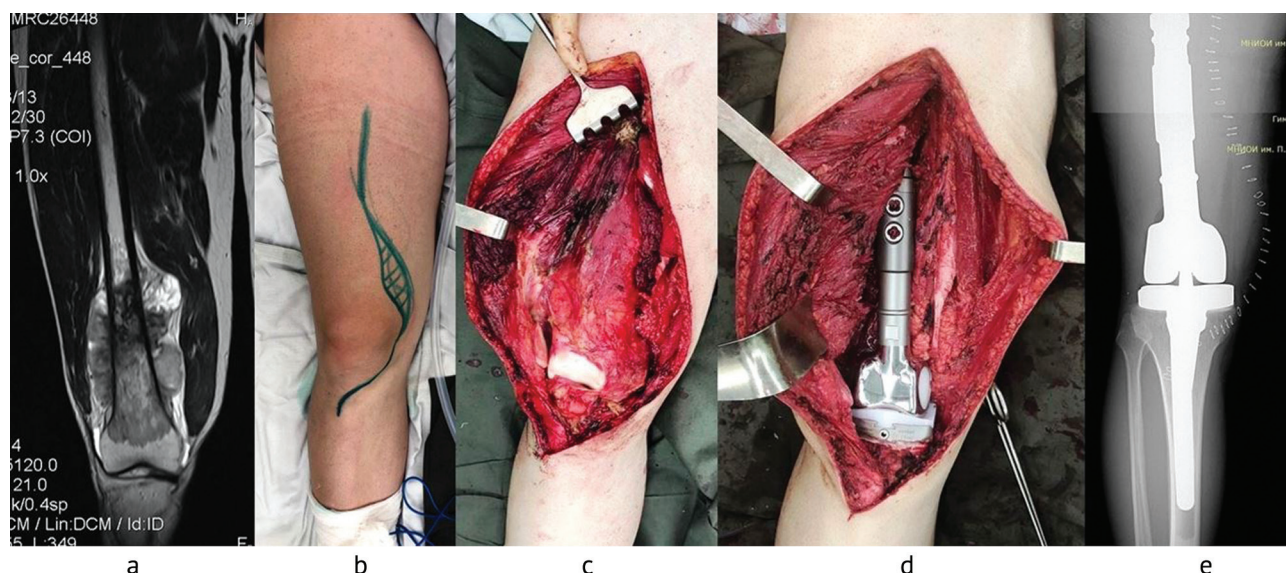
MRI of osteosarcoma of the distal femur (a); surgical access (b); tumour mobilized from surrounding soft tissues (c); knee joint implant (d); radiograph after surgery (e)
